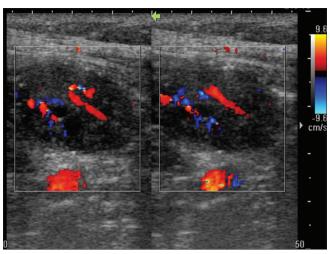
Sonographic examination showing a 6 cm \times 4 cm heterogenous-echoic pattern of solid mass of the sigmoid
